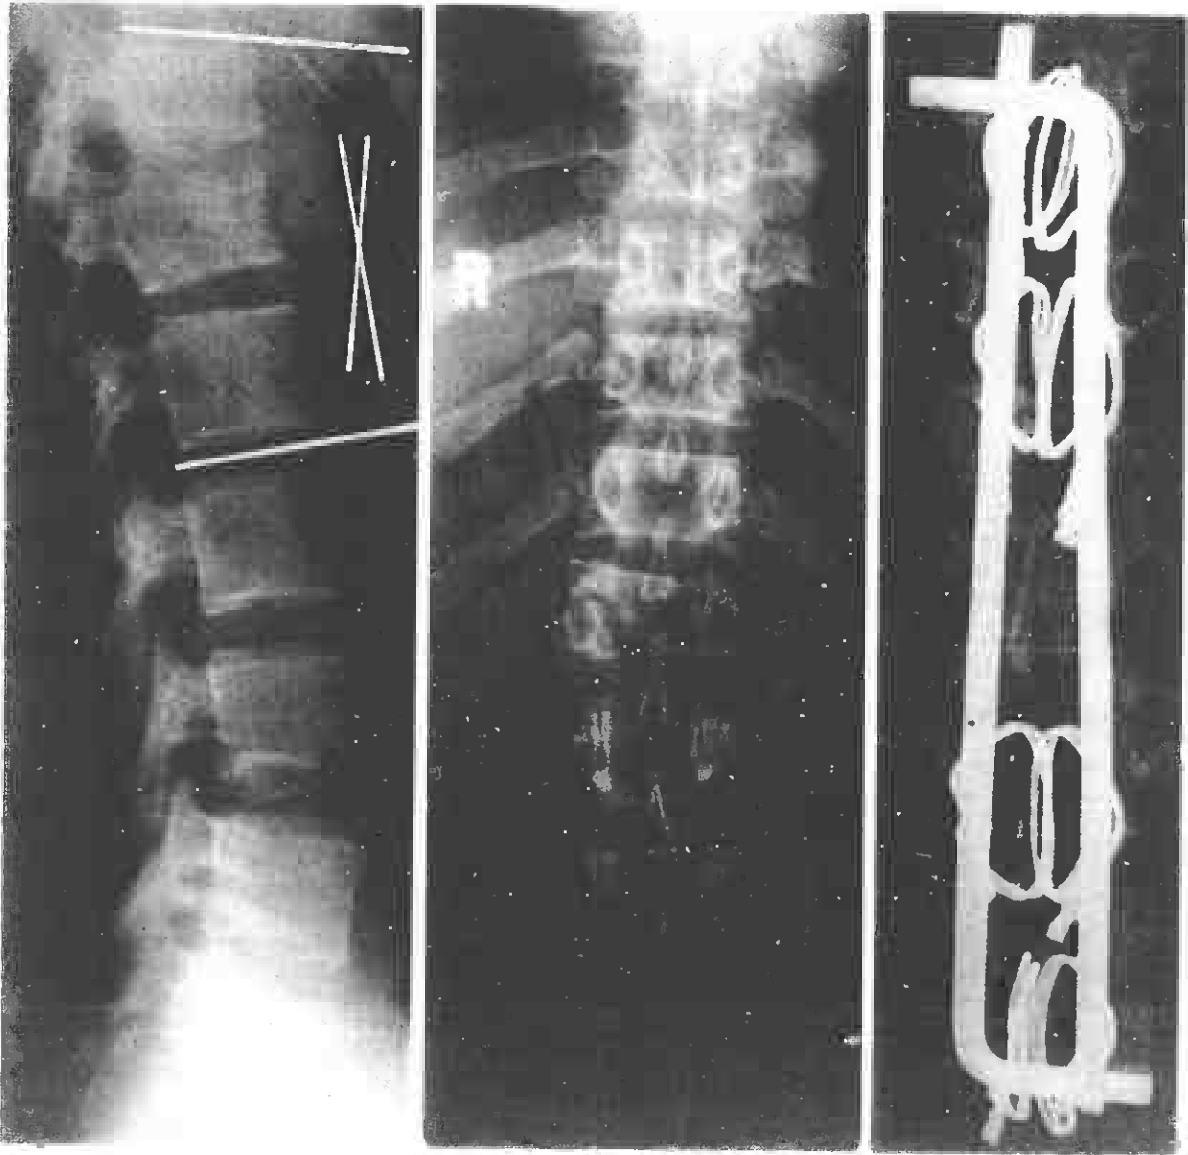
(a) Anteroposterior and lateral Radiographs of P.P.
